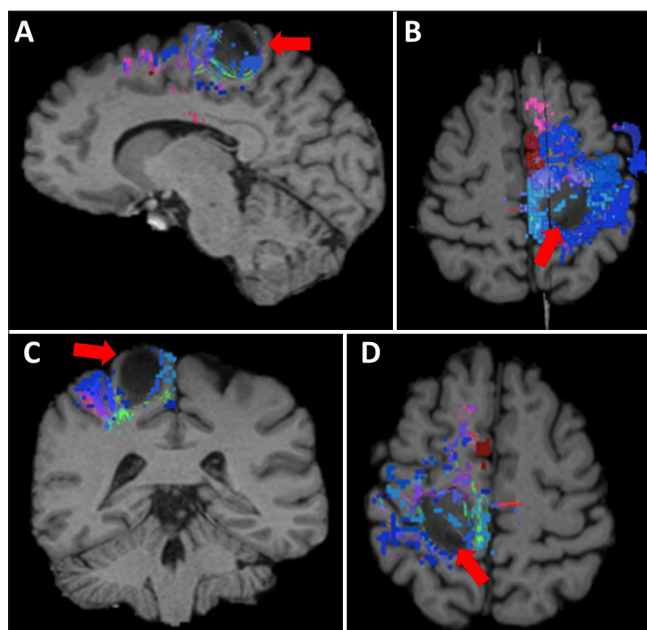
Preoperative planning of the sensorimotor network using connectome-guided neuronavigation, demonstrating functional areas within the lesion. (A) Sagittal MRI view obtained using connectome-guided neuronavigation, with the tumor indicated by a red arrow; (B) axial view highlighting that the software reverses left-right orientation during image reconstruction, with the tumor indicated by a red arrow; (C) coronal view intentionally inverted to normalize laterality, with the tumor indicated by a red arrow; and (D) axial view, with the tumor indicated by a red arrow.
